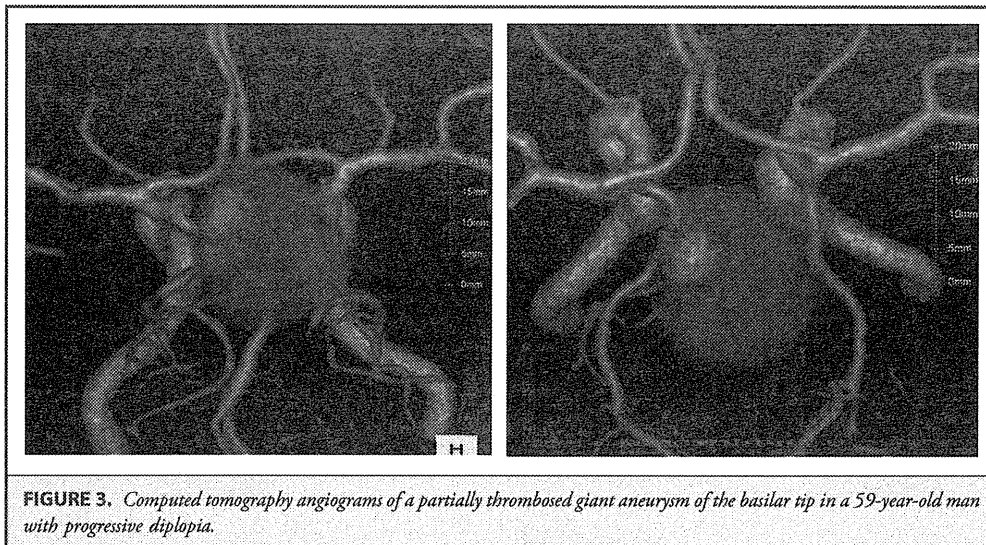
Computed tomography angiograms of a partially thrombosed giant aneurysm of the basilar tip in a 59-year-old man with progressive diplopia.*
